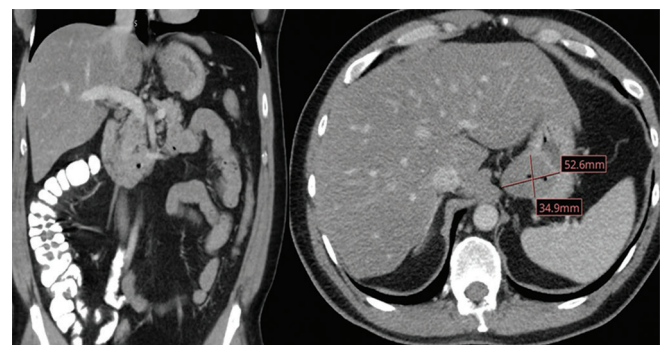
CT abdominal/pelvis with contrast; coronal and axial views from case 3L abnormal soft tissue seen at the level of the gastroesophageal junction of the stomach.
